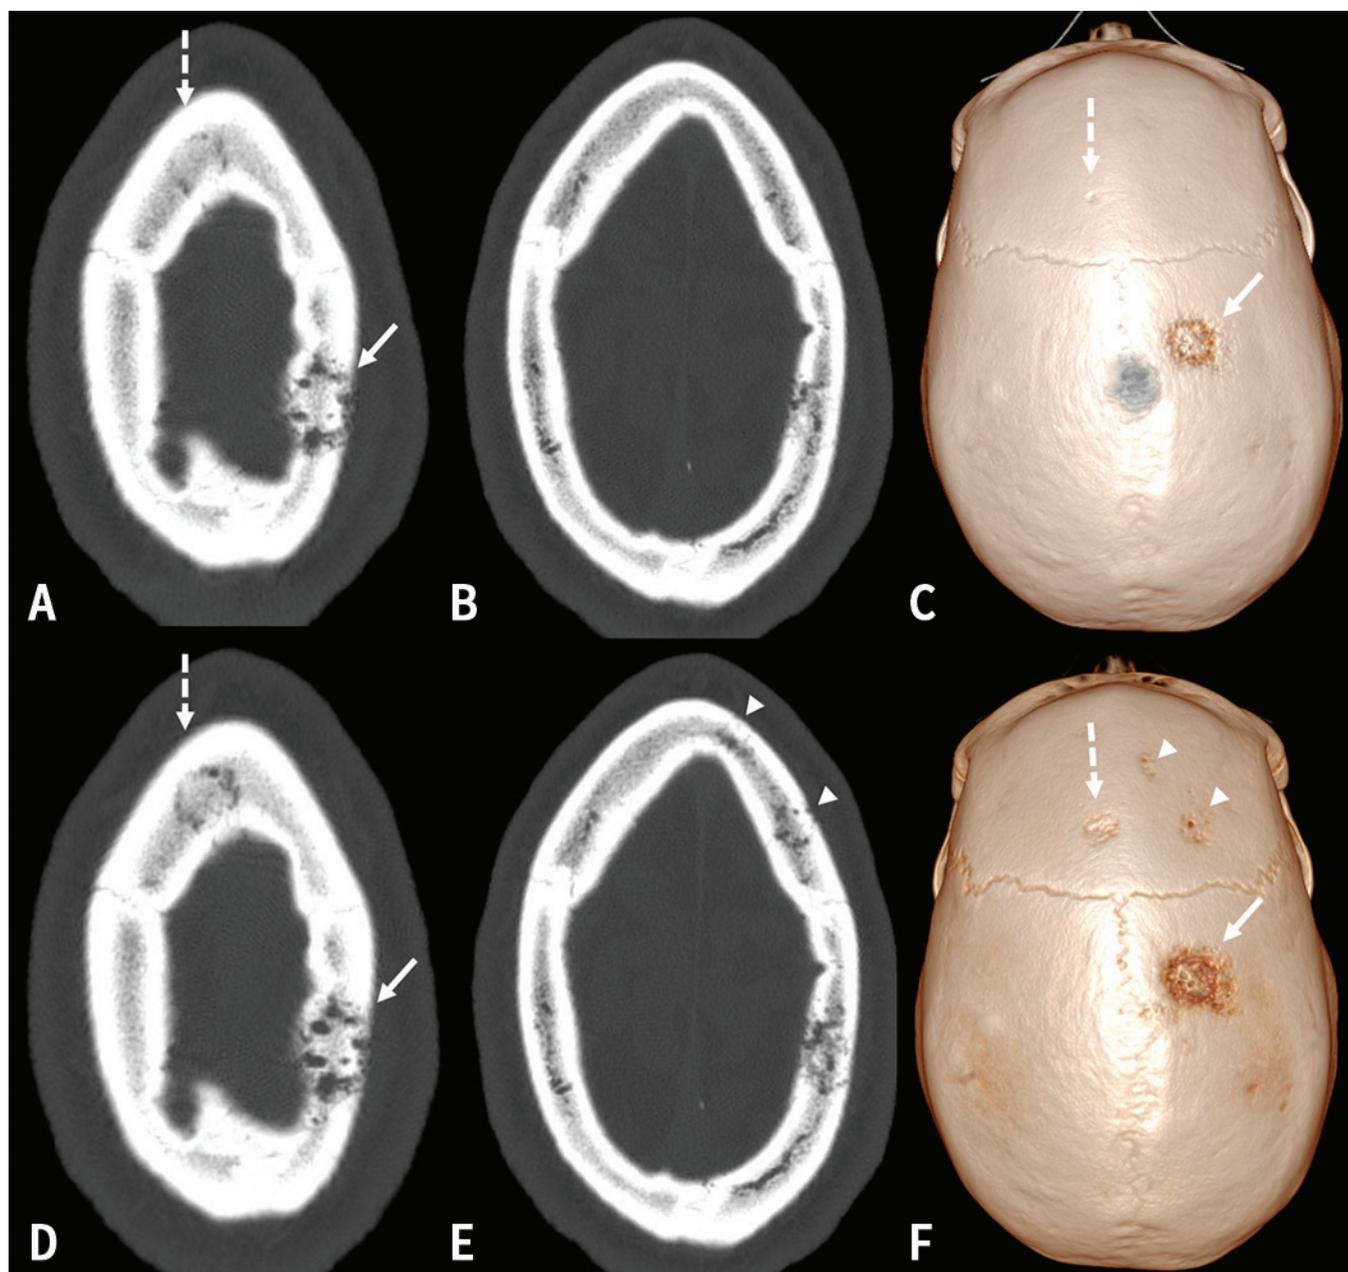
Osseous changes in syphilitic osteomyelitis in a 25-year-old man. (A, B) Axial initial computed tomography (CT) images show a circular area of bone destruction with an irregular tubular (worm-like) appearance (arrow). (C) A 3-D volume-rendered (VR) initial CT image shows this lesion. (D, E) Axial CT images after 2 weeks of treatment show 3 similar additional lesions in the frontal bone, which are subtle (dashed arrows) or not seen (arrowheads) on the initial CT. The dominant lesion also shows minimal progression of osseous destruction (arrows). (F) A 3-D VR image shows these lesions well.
